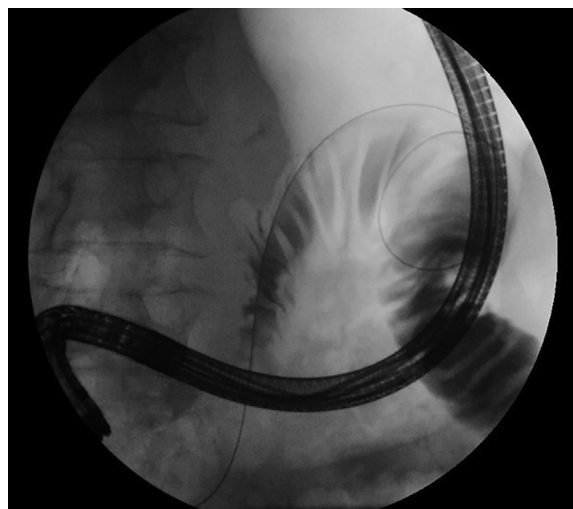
Abdominal radiograph demonstrating placement of a guidewire across the duodenal obstruction with a loop in the proximal jejunum.
